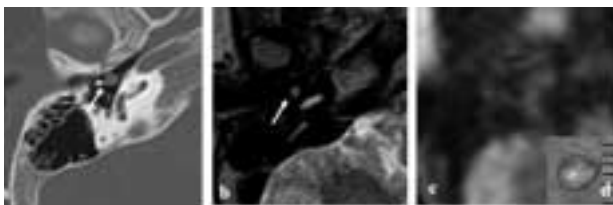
false negative case of congenital cholesteatoma (case 3), Axial CT and MRI findings (a) CT, (b) T2WI, (c) DWI, (d) extraction cholesteatoma, arrow: cholesteatoma
